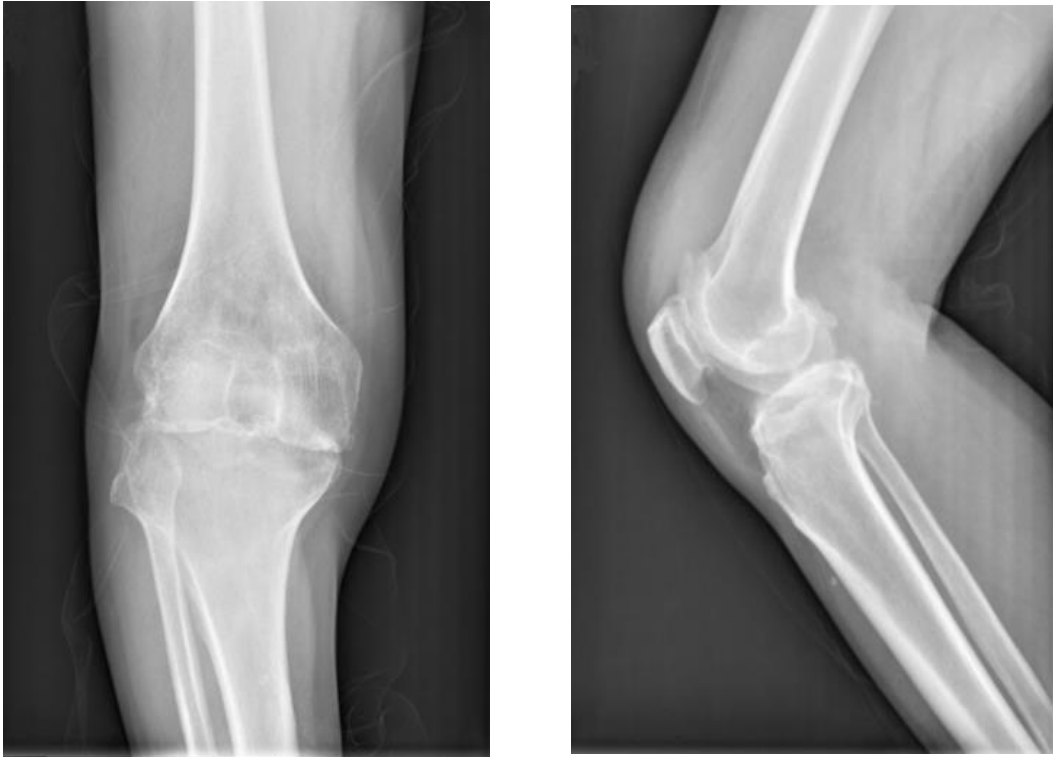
Radiography of the right knee joint showing degenerative changes (left: frontal view; right: lateral view)
